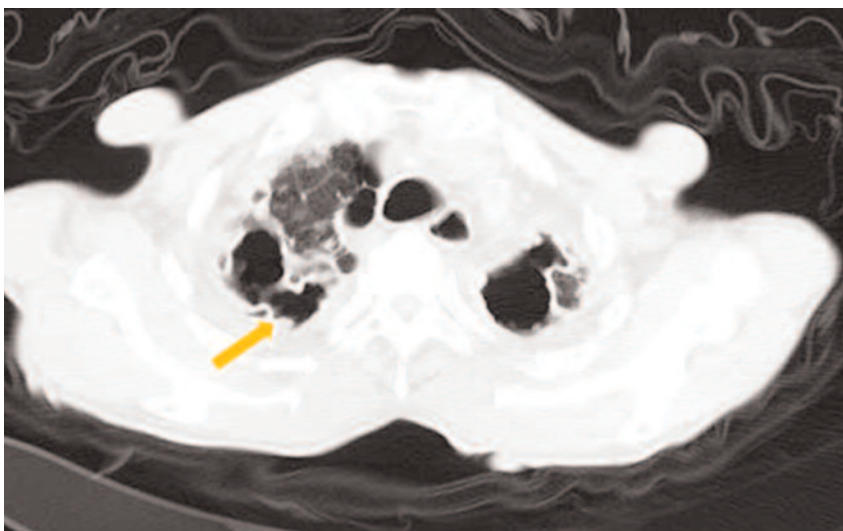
Chest CT scan shows bilateral large cavities in the 53-year old man with *Mycobacterium kansasii* induced lung infection.
